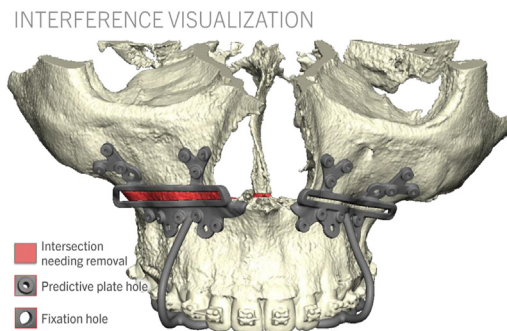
3-D rendering created from a preoperative CBCT scan highlighting anticipated bony interferences and placement of custom cutting guides for a planned LeFort 1 osteotomy advancement.
